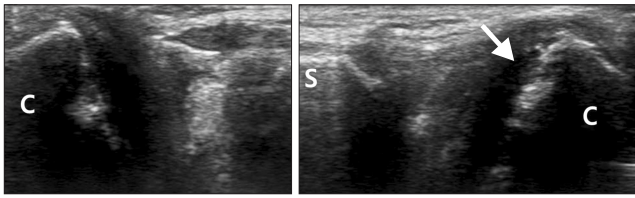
Ultrasound scan of the sternoclavicular joints after postoperative 8 weeks. Long axis sonographic image of the medial clavicles demonstrates the normally located left medial clavicle (arrow). S: sternum, C: clavicle.
